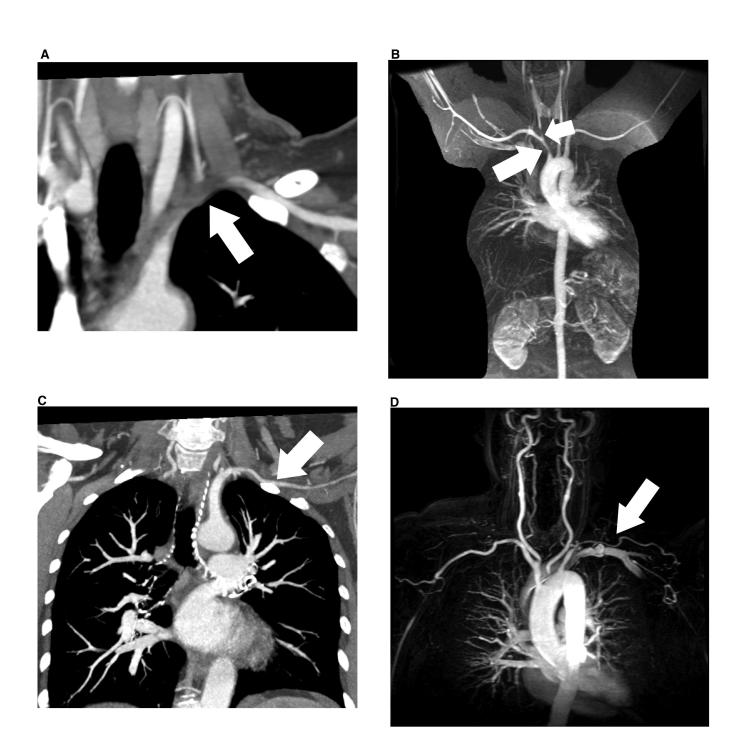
Typical images of TAK and GCA in subclavian artery lesion. A. Tight and short stenosis of subclavian artery in TAK by CT. B. Short stenosis of proximal common carotid and brachiocephalic arteries in TAK by MRI. C. Long tapered stenosis of subclavian artery in GCA by CT. D. Long tapered stenosis of subclavian artery in GCA by MRI. TAK: Takayasu arteritis; GCA: giant cell arteritis; CT: computed tomography; MRI: magnetic resonance imaging.
